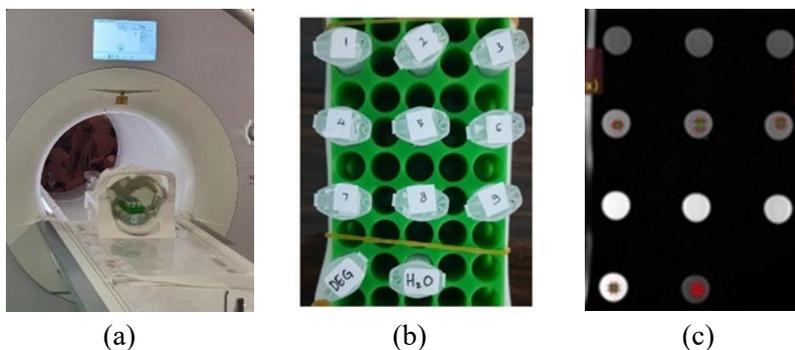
(a) positioning settings on the MRI 3T (b) GdNP solution and the solvent in the microtube (c) Imaging results of GdNP using MRI 3T
